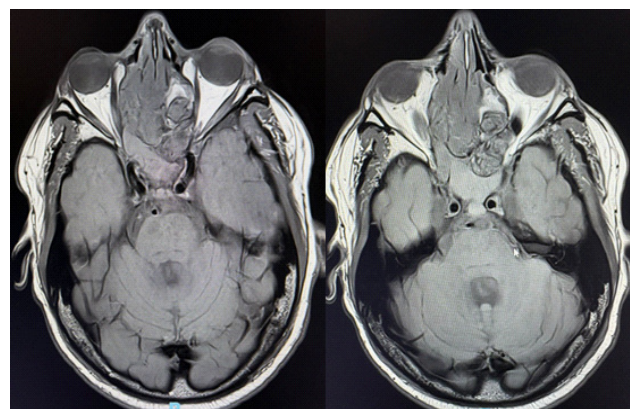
Axial T1-weighted MRI images with gadolinium contrast, showing a large ethmoid-centered tumor with heterogeneous enhancement. The mass invades the nasal cavity, right orbit, and erodes the cribriform plate, with anterior cranial fossa extension.
